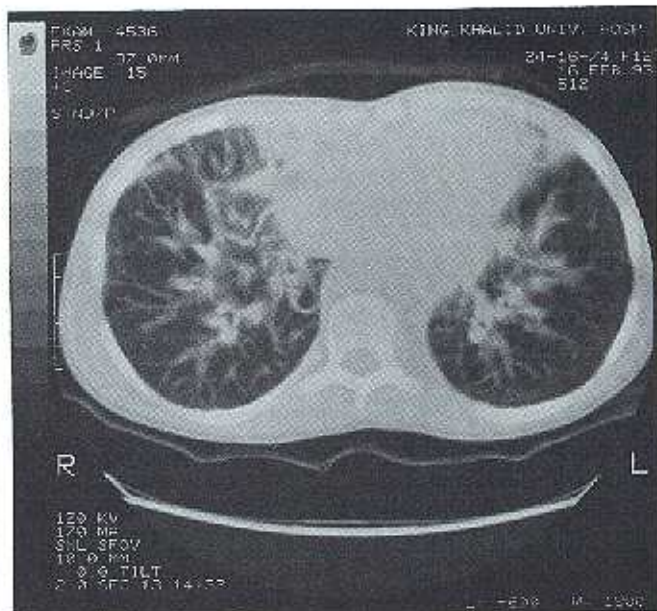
CT scan of the chest showing mediastinal widening and diffuse distended lymphatics in the lung fields.
